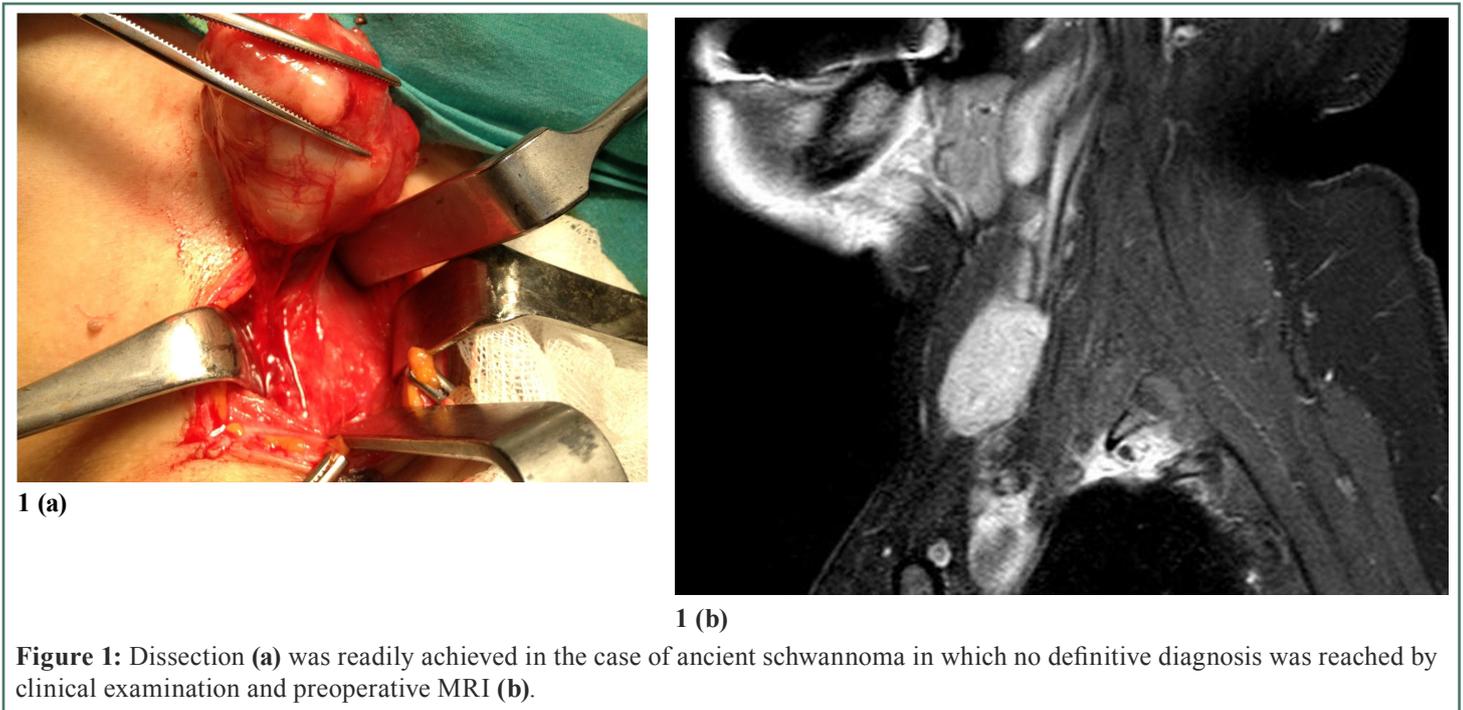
Dissection (a) was readily achieved in the case of ancient schwannoma in which no definitive diagnosis was reached by clinical examination and preoperative MRI (b).
